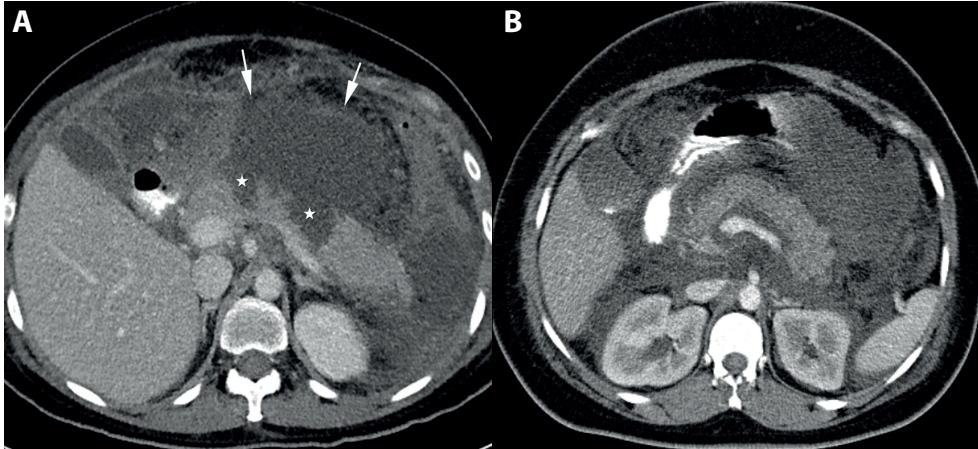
Combined necrosis and extrapancreatic necrosis. (A) CT shows nonenhancing parts of pancreatic neck and body (asterisks) with surrounding acute necrotic collections (arrows). (B) CT depicts a normal enhancing pancreatic parenchyma surrounded by acute necrotic collections. Note, calcified stone in the gallbladder.
